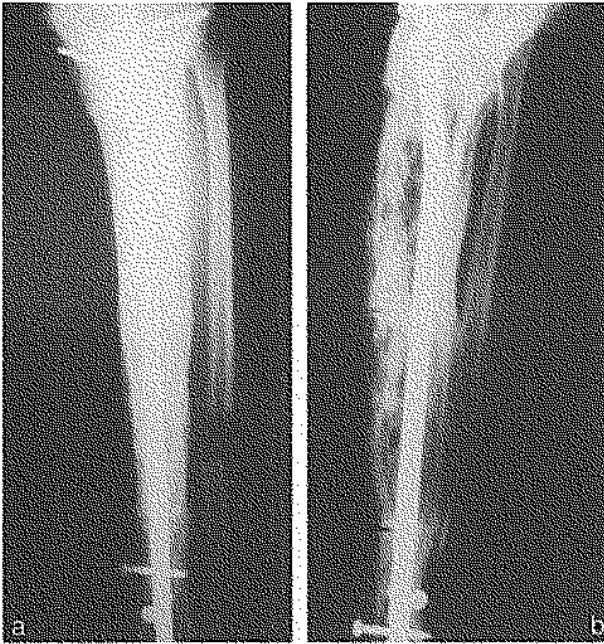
AP radiograph after surgery.
